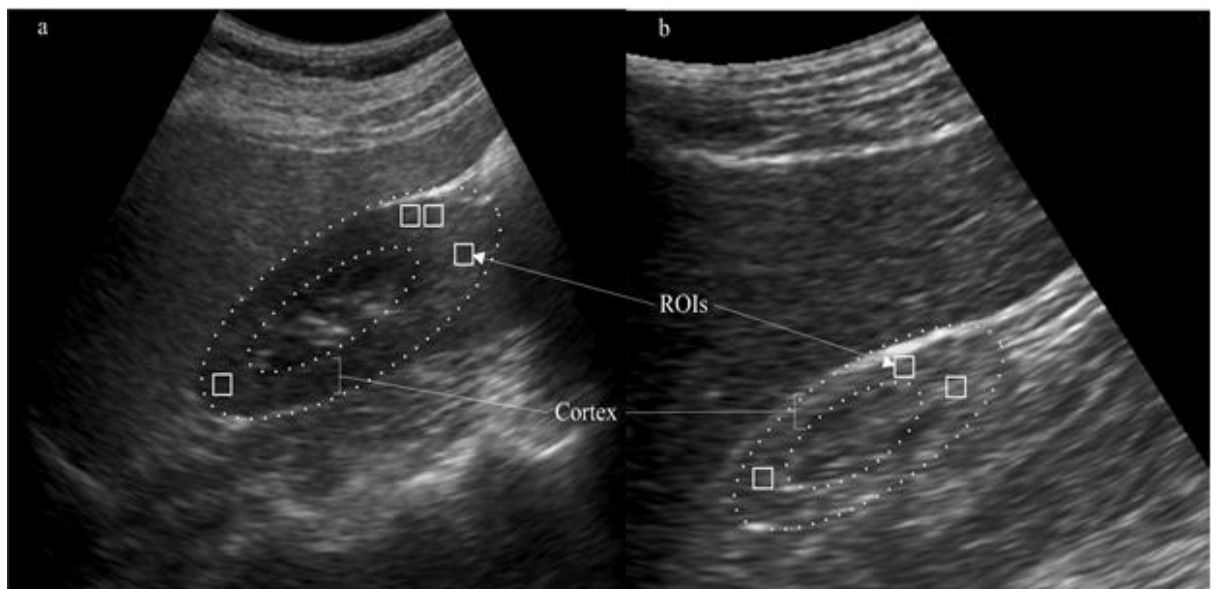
Example of B-mode Ultrasound kidney images with ROIs marked. A Normal and b MRD. The dots forming outer ellipse highlights the kidney and the area between the two ellipses represents cortex.
